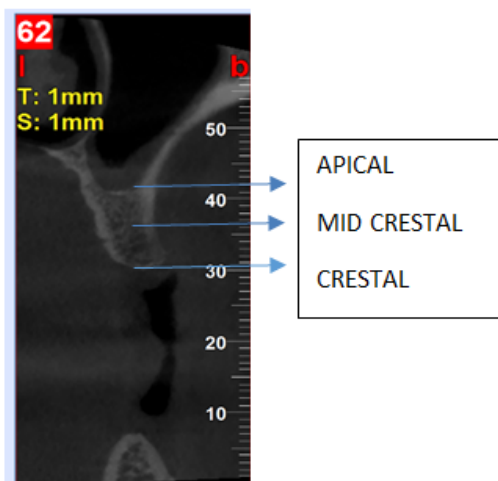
CBCT representation of 3 different bone levels
